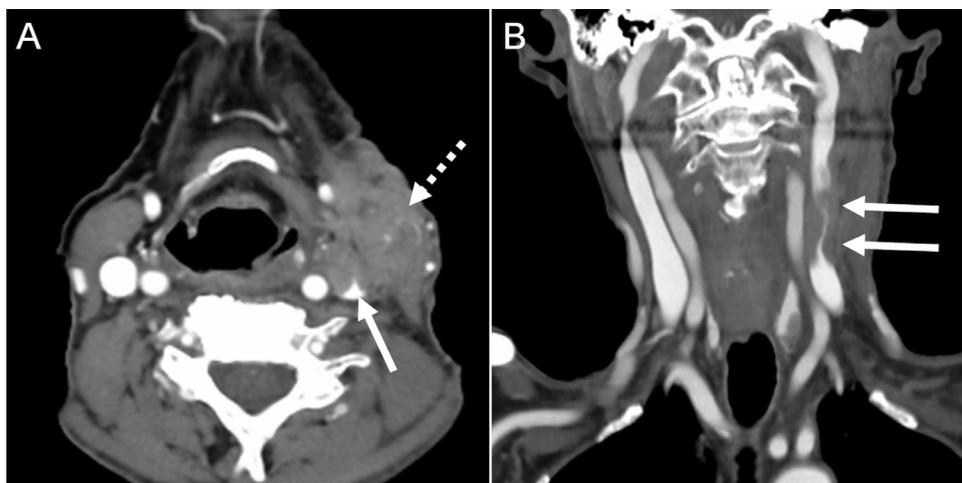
A 79-year-old with follicular lymphoma presents with shortness of breath. A postcontrast CT study of the neck (A,B) shows a large nodal mass within the left level II and III nodal stations (A, dashed arrow) with resultant tumor thrombus that extends into the left internal jugular vein (A-B, solid arrows).
